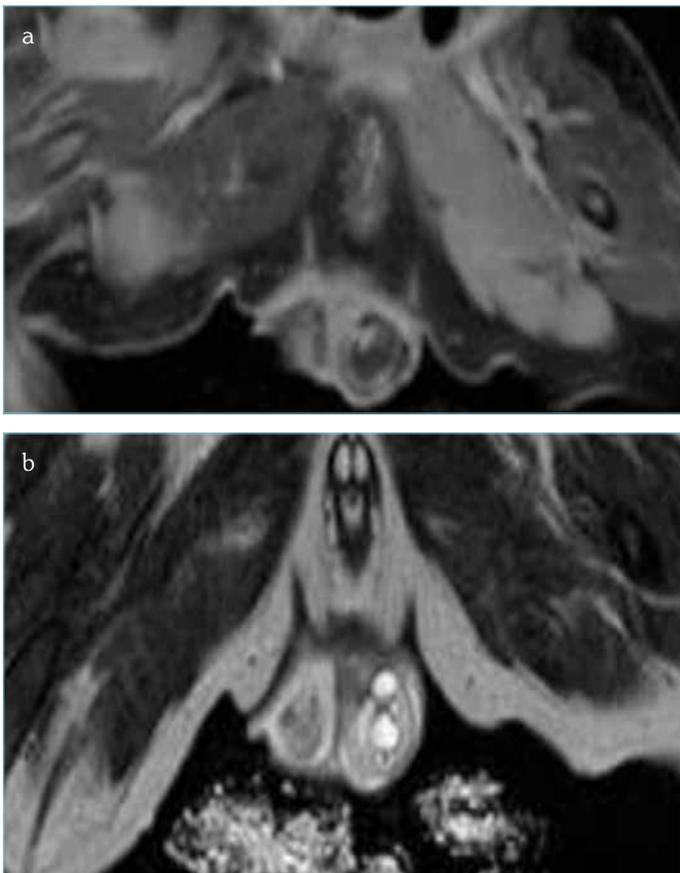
a, b. Contrast, T1A coronal section(a) and T2A coronal section (b); Magnetic resonance image of the left testis scrotum. Mass lesion with a regular contour, cystic area, and areas of septal contrast uptake measuring 15×11 mm
